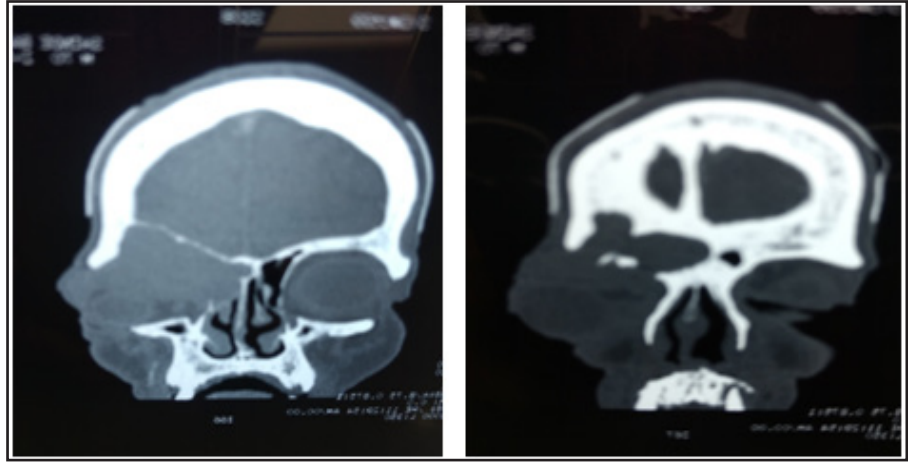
CT shows non-enhancing soft tissue density lesion involving right frontal and ethmoid sinuses
